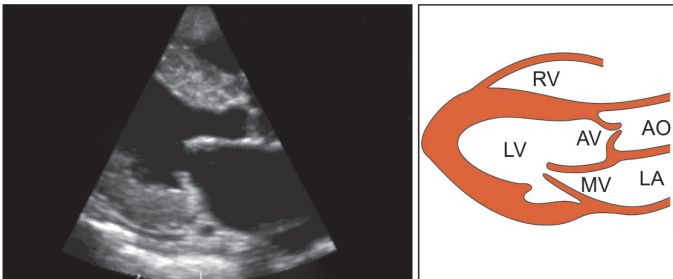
The parasternal long-axis (PLAX) view
